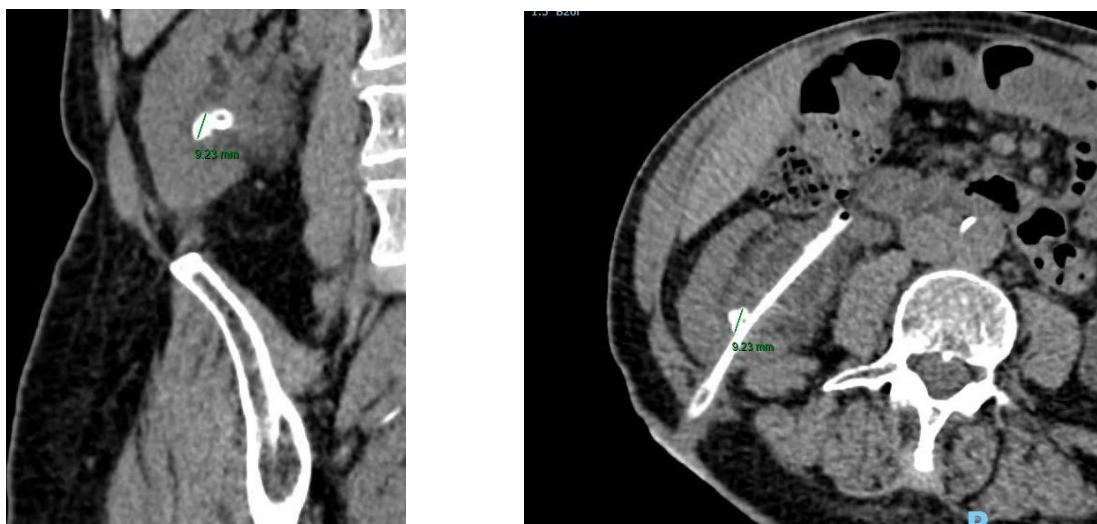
non-contrast abdominopelvic CT scan obtained at subsequent follow-up, showing a tendency towards calcification of the right PCN. In the image, calcification adhering to the tube with a maximum diameter of 9.2 mm x 9.2 mm. It can also be seen in coronal section, occupation of the lumen of the device by calcium dense material.
